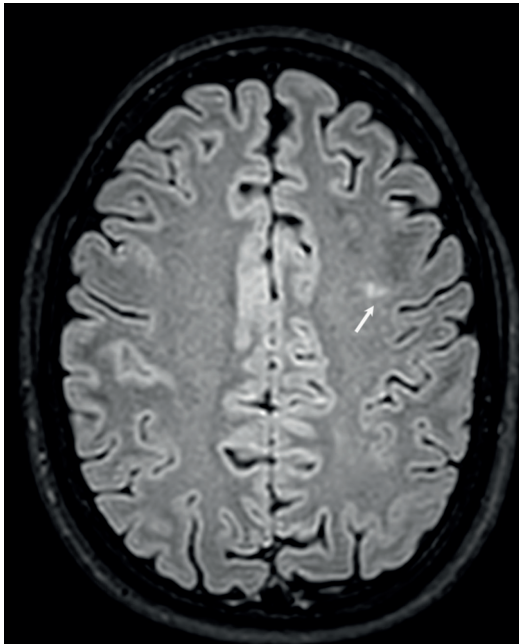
Axial T2-FLAIR brain MRI shows multiple small foci of hyperintensity localized in left fronto-parietal white matter (white arrow).
